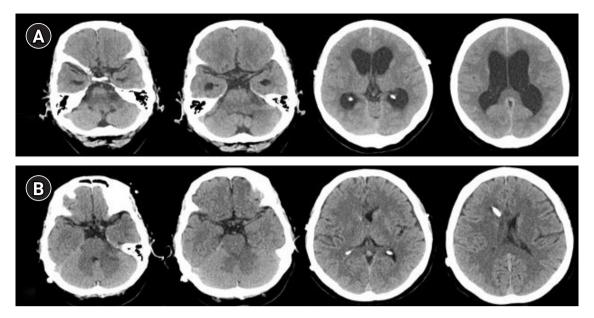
Non-contrast computed tomography (CT) images of the patient. (A) Three months after gamma knife surgery, follow-up CT scans revealed enlarged ventricles. (B) After ventriculoperitoneal shunt insertion, the size of the ventricles normalized.
